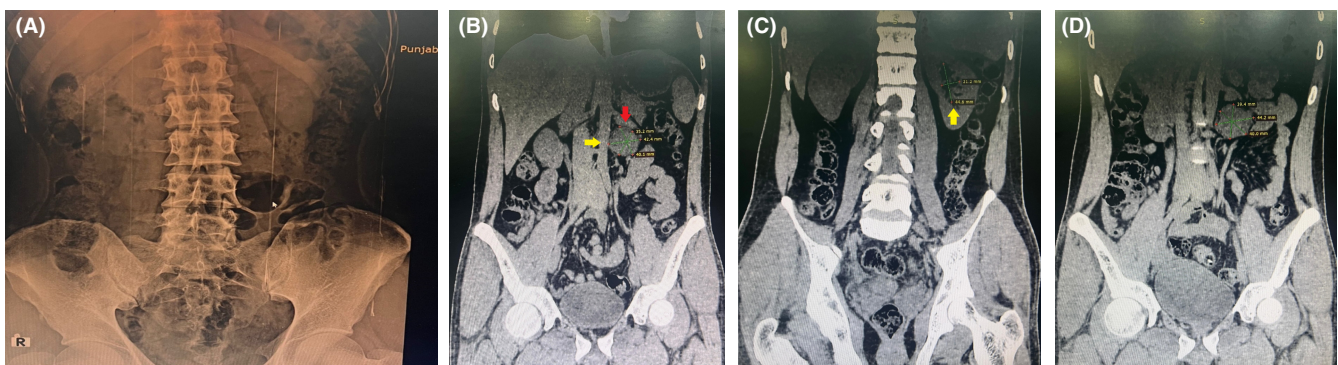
(A) X-Ray KUB showed no signs of any soft tissue mass. (B) Triphasic Abdominal CT displaying a 42.4×40.1×35.2 mm round, encapsulated, well circumscribed, homogenous mass in the left retroperitoneum impinging infrarenal aorta towards midline (yellow arrow), Left Renal artery superiorly (red arrow). (C) CT-KUB suggestive of Mild left sided hydronephrosis (yellow arrow), likely due to retroperitoneal mass impinging on the left ureter. (D) CT-KUB showing a well-defined encapsulated mass in close relation to vascular structures.
